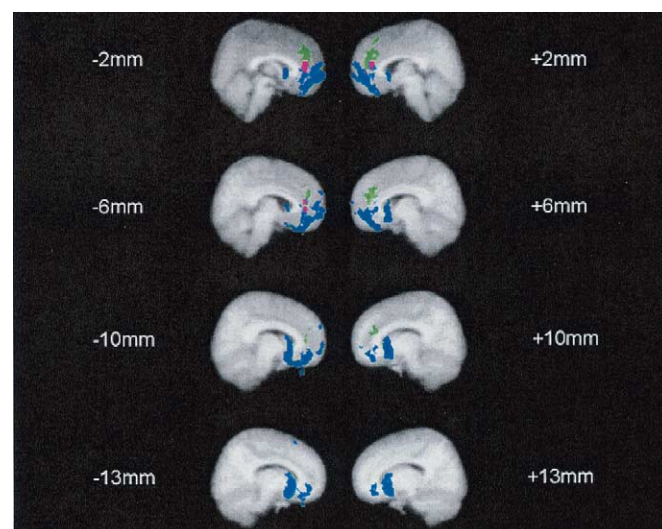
Green areas represent regional increases in blood-oxygenated-level-dependent (BOLD) response during decisions in which the experimental gamble was associated with large compared with small gains; blue areas represent regional increases in BOLD response associated with those trials in which the participants won monetary reward (good outcomes) in the outcome phase compared with trials in which they lost (bad outcomes); pink areas represent overlap of green and blue. Rendered on mean T1-weighted images (for 14 participants) after transformation into standard space.
